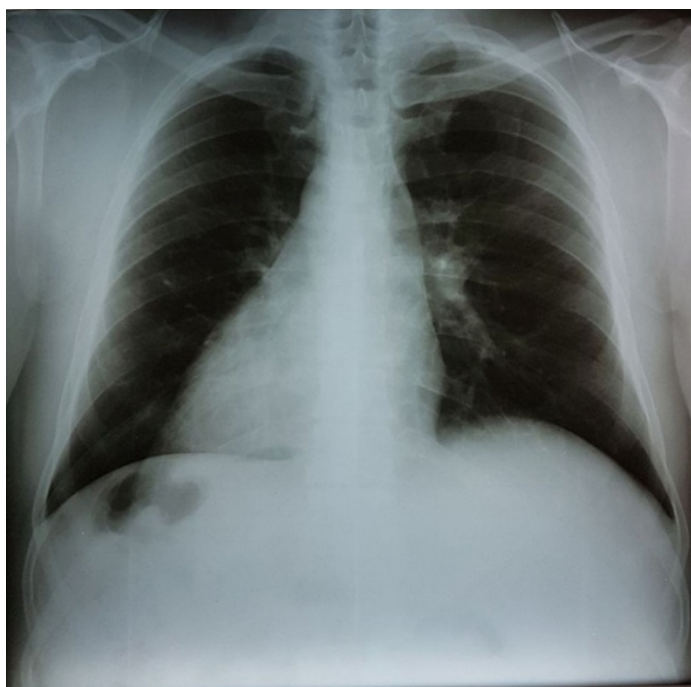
PA Chest x-ray – Dextrocardia.
